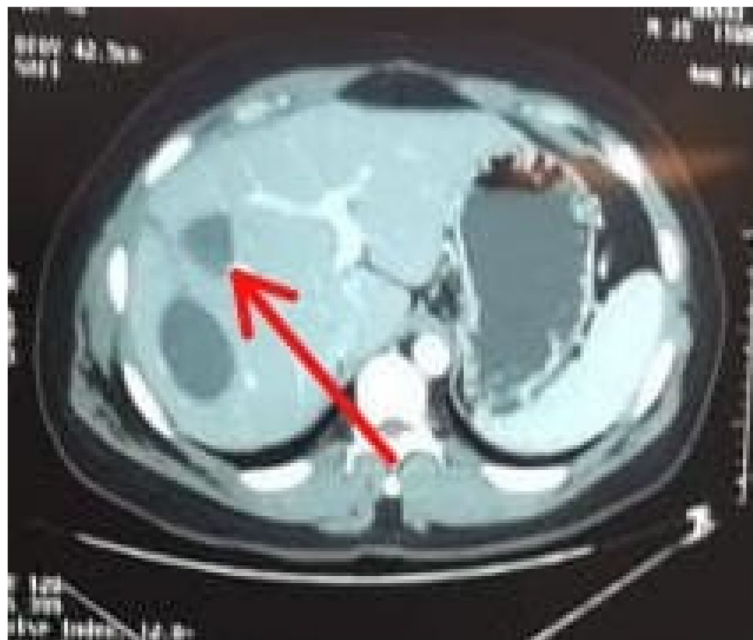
Axial CT showing hypodensity (red arrow) near porta hepatis depicting hydatid cyst
